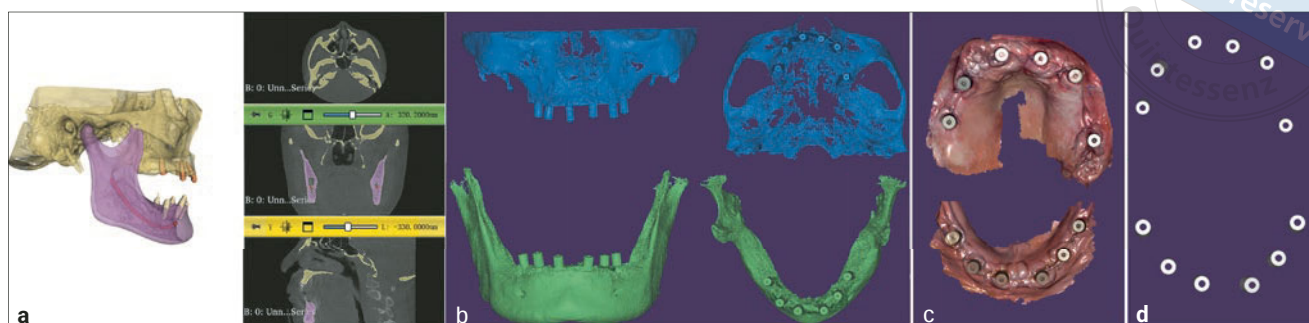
to d Data acquisition for multimodal integration. Postoperative segment of maxillary and mandible using 3D Slicer (a); postoperative CBCT data (b); acquisition of information relating to soft tissue morphology around implants and ICamRefs bevels (c); acquisition of implant position data (d).
